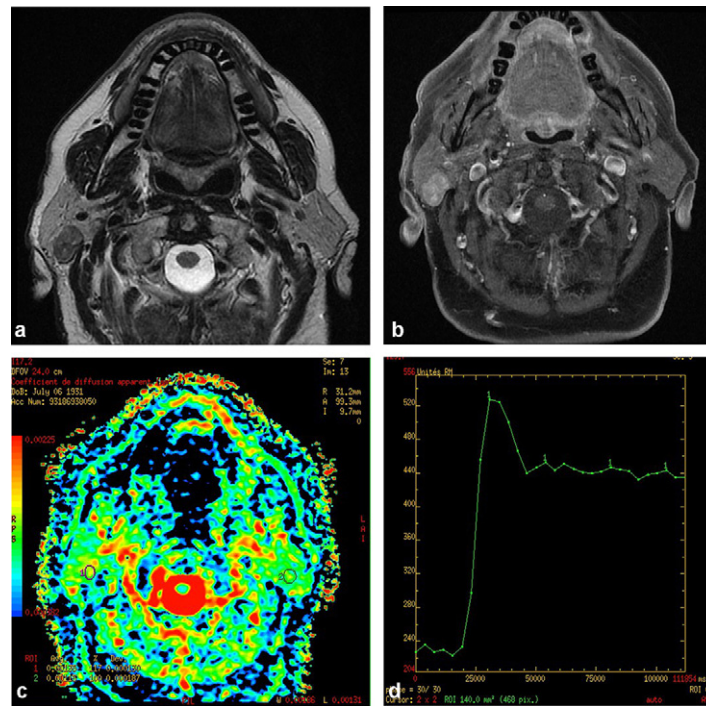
Intermediate-grade tumor. Tissular formation of the superficial right parotid: a: T2-weighted axial slice: low signal on T2-weighted image; b: T1-weighted gadolinium-enhanced fat-sat axial slice: moderate uptake; c: apparent diffusion coefficient map: ACDr = 1.1; d: perfusion curve showing early uptake with wash-out less than 30%.
